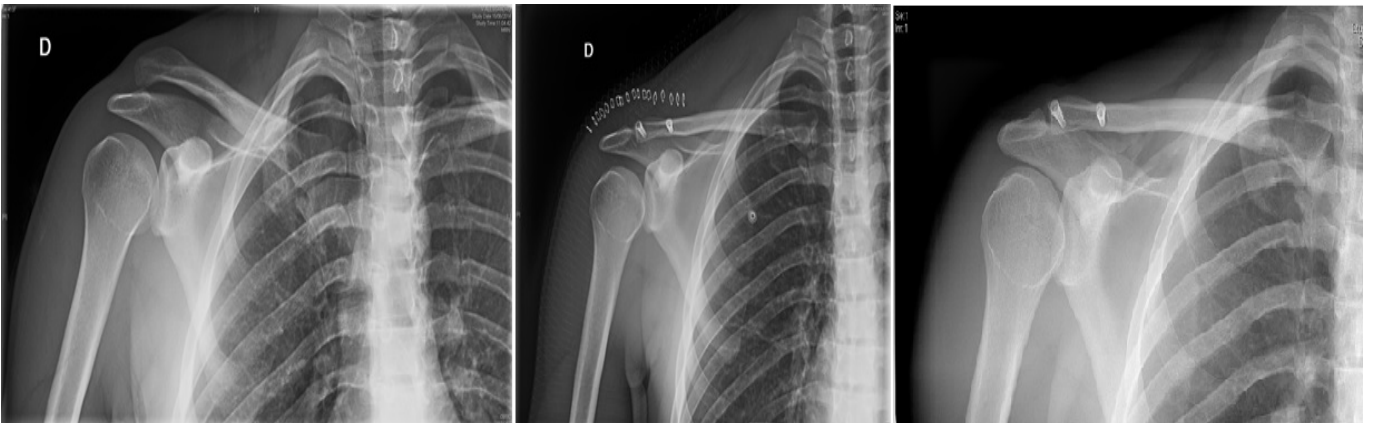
Radiography of acromion clavicular dislocation Rockwood type III. A) Initial injury; B) follow-up performed after surgery; C) final follow-up performed at 12 months after surgery.
